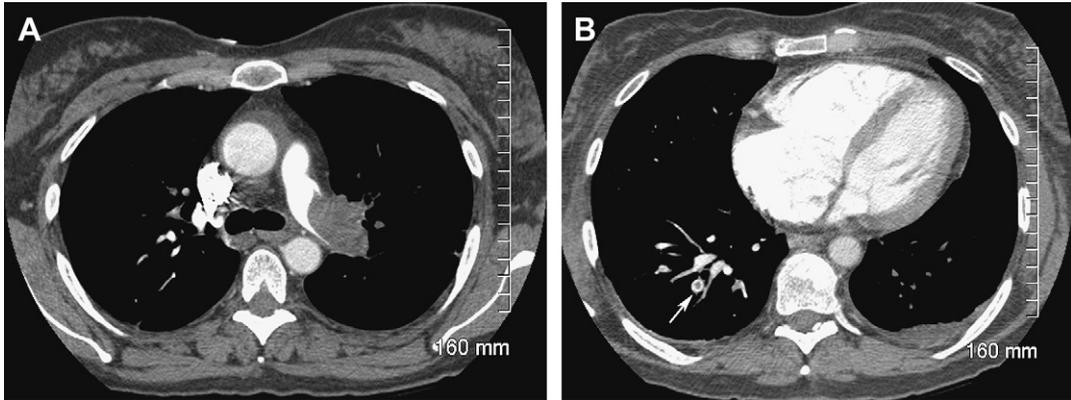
(A) CTA demonstrates acute PE in the left main pulmonary artery as a complete filling defect; the vessel is enlarged. (B) At the level of ventricles, a central partial filling defect of the acute PE (arrow) is seen in the right lower lobe posterobasal segmental artery (Polo mint sign). Right ventricle and right atrium are moderately dilated, suggesting right heart strain.
